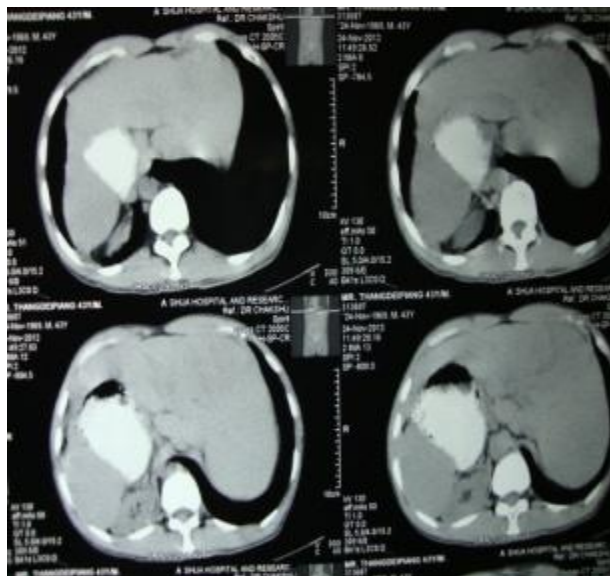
CT image showing situs inversus totalis
